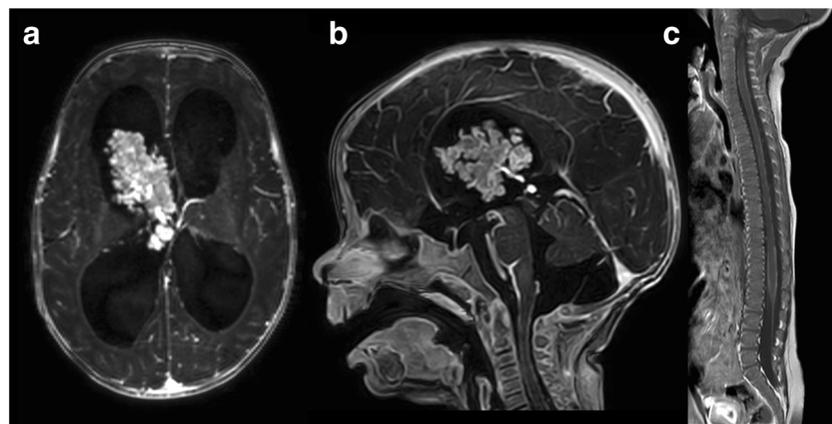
Brain and spinal MRI at diagnosis. a Axial TFE with gadolinium shows a lobulated mass with strong enhancement in the lateral ventricle, with close relationship with the choroid plexus and extension into the III ventricle. Hydrocephalus. b Sagittal TFE with gadolinium. Diffuse
